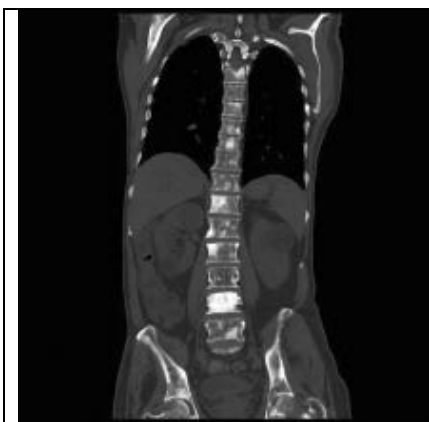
Pain spinal metastases on CT scan.
